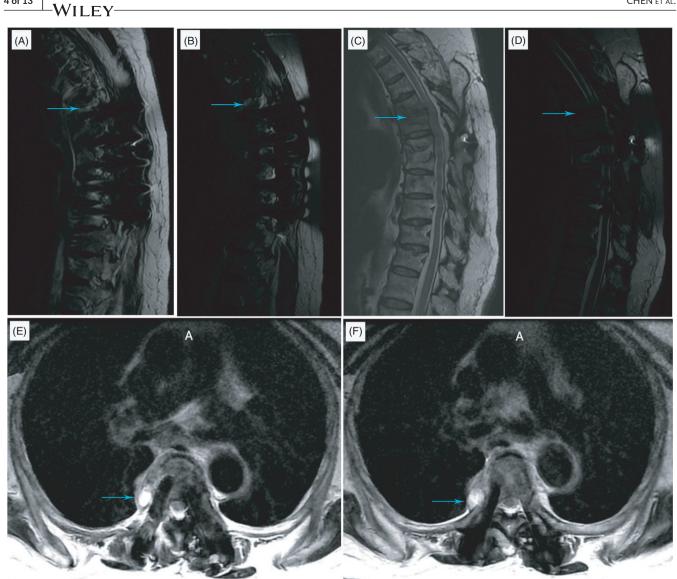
Preoperative MRI examination performed during the second surgery. (A) The arrow points to the T5/6 paraspinal abscess in the T2 sequence. (B) The arrow points to the T5/6 paraspinal abscess in the T2 lipid pressing sequence. (C) The arrow points to the T5/6 intervertebral space lesions in the T2 sequence. (D) The arrow points to the T5/6 intervertebral space lesions in the T2 lipid pressing sequence. (E and F) The arrow points to the T5/6 paraspinal abscess in the T2 sequence cross section
